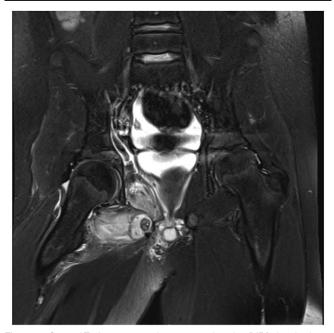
Coronal T2 fat sat magnetic resonance imaging (MRI) showing bone involvement in the pubic area with ischium subperiosteal abscess, and enhancement rim of the externus obturator.
